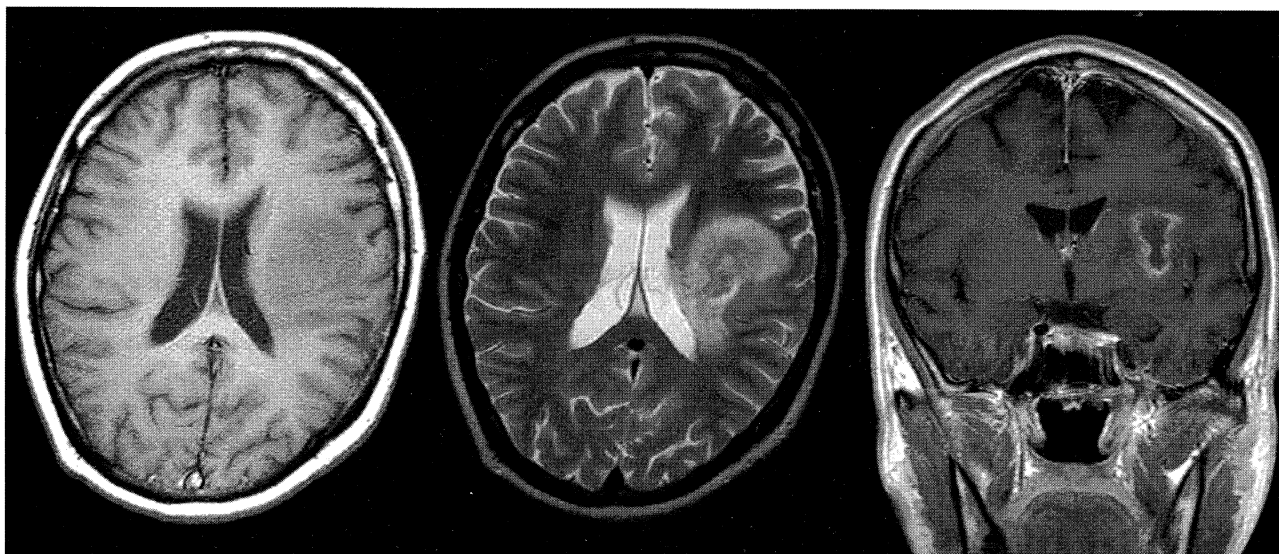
Brain MRI demonstrating a mass lesion in the white matter of the left hemisphere which was visualized as low intensity signal on T1-weighted image (left), high intensity signal on T2-weighted image (middle), and ring-enhancing on gadolinium-enhanced T1-weighted image (right).
